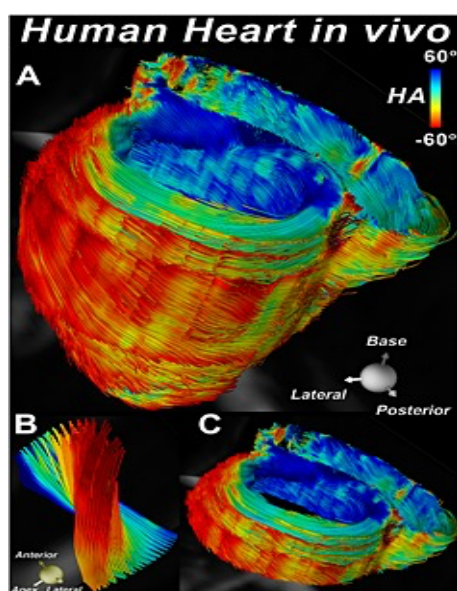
DTI MRI of the heart. <sup>95</sup>
